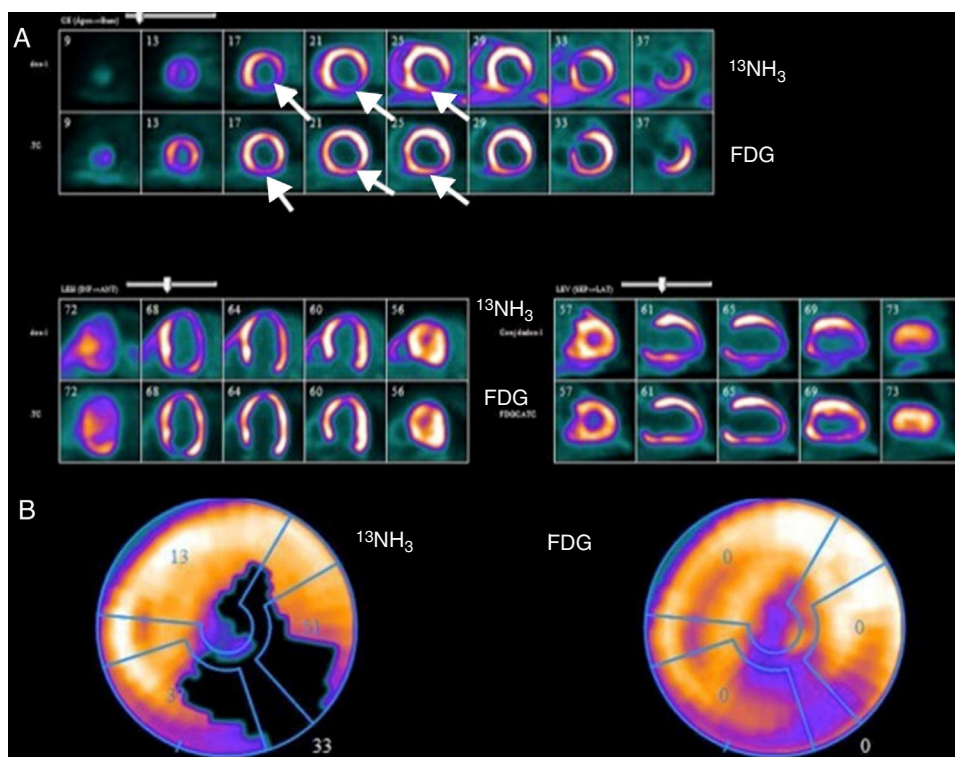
Example of assessment of myocardial viability with positron emission tomography imaging. (A) Top rows: ^{13}N -labeled ammonia ($^{13}\text{NH}_3$) is used as a tracer of myocardial blood flow at rest in short-axis images starting at the apex and moving toward the base of the heart (upper image), horizontal long axis (lower left) and vertical long axis (lower right). Myocardial perfusion is markedly decreased in the apical, inferior and inferolateral regions (white arrows); Bottom rows: ^{18}F -2-fluoro-2-deoxyglucose (FDG) is used as a tracer of myocardial glucose metabolism. FDG uptake is enhanced relative to blood flow, demonstrating a pattern of perfusion-metabolism mismatch (white arrows) in the abnormally perfused myocardial regions, indicative of viable or hibernating myocardium; (B) polar map of viability study. The left polar map plot displays the extent of the rest perfusion defect (black area); the right polar map plot shows FDG uptake in the rest perfusion defect area indicating metabolic viability. Image source: Instituto das Ciências Nucleares Aplicadas à Saúde (ICNAS).
